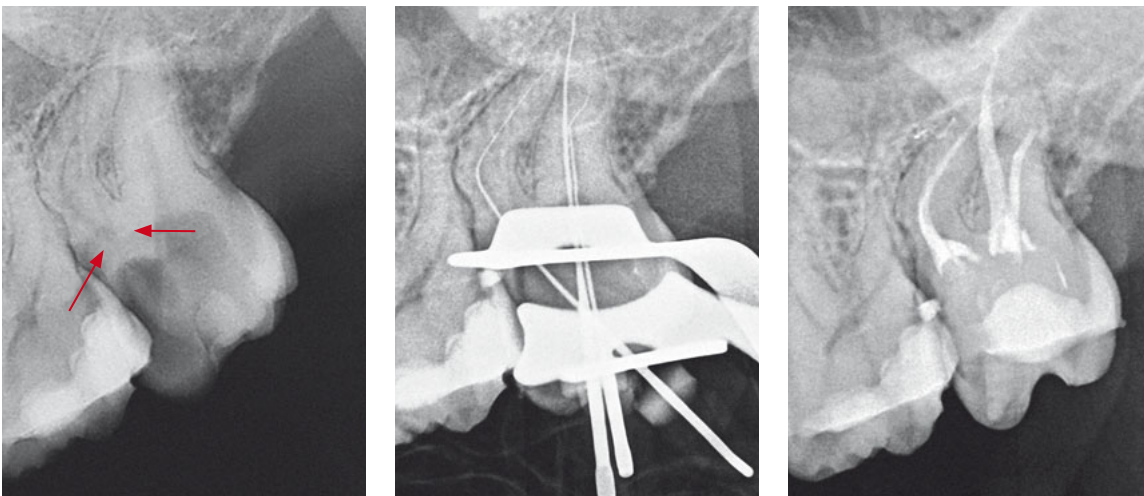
The root canals of the maxillary molar were radiographically recognisable but direct access to both mesiobuccal canals was not possible, because of the formed tertiary dentine.
